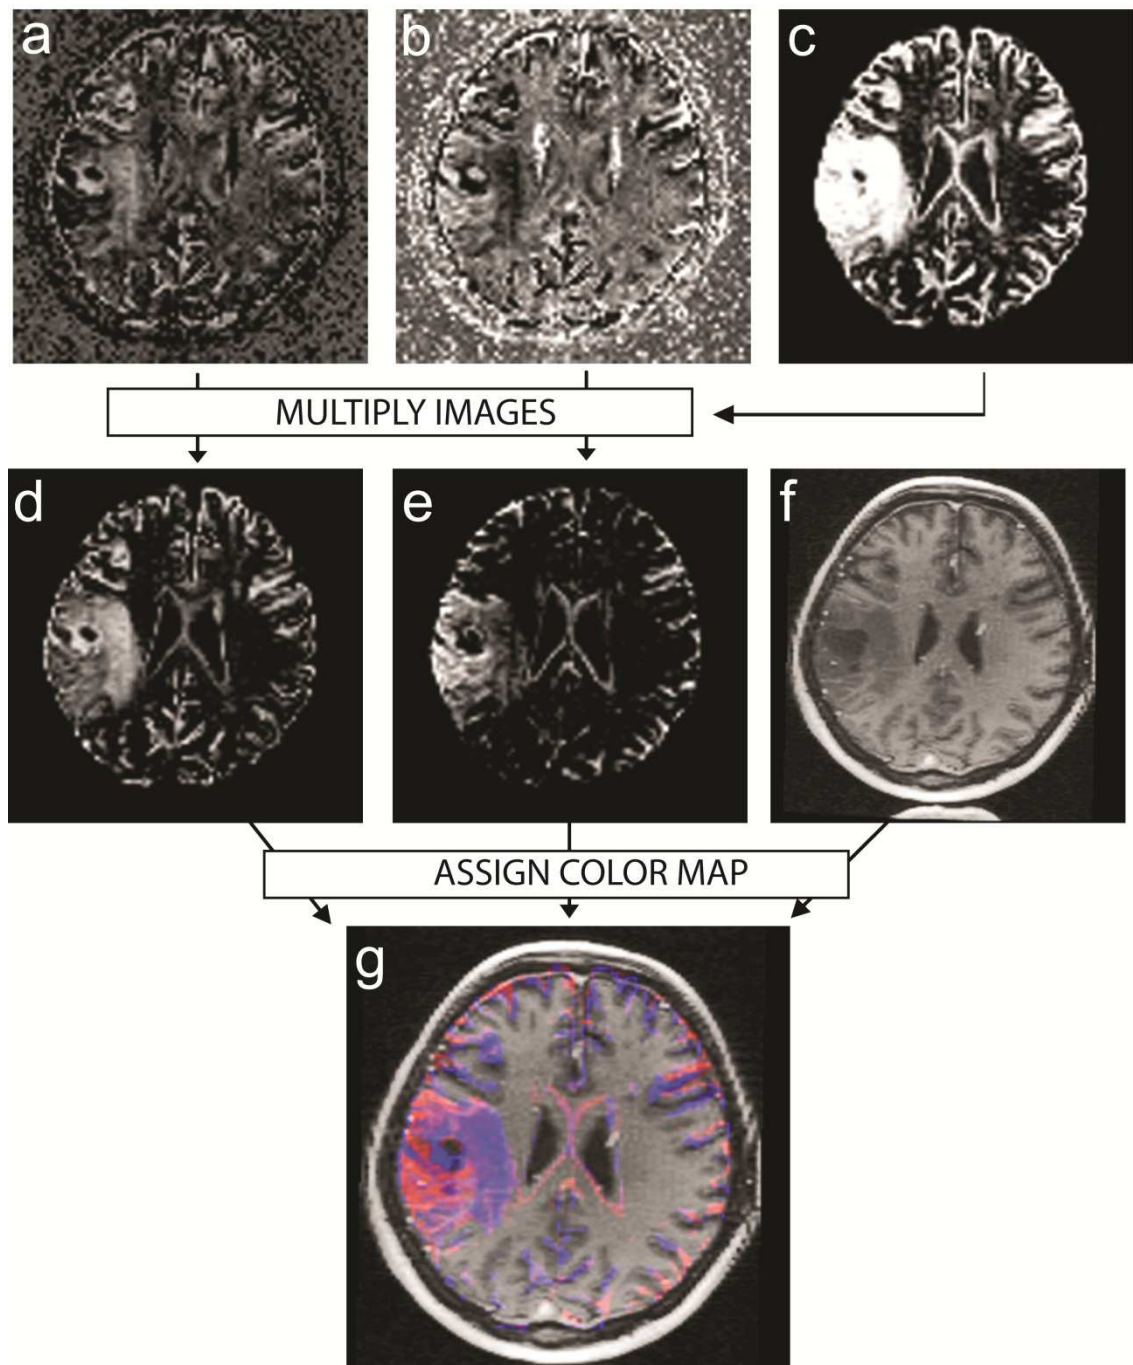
Glioma grade map generation: calculation of intermediate grayscale images and the color-coded glioma grade map (study specific aim C/2). (a) Low grade tumor probability map (LGPM), (b) High grade tumor probability map (HGPM), (c) Tumor probability map (TPM), (d,e) LGPM and HGPM weighted with the TPM, (f) T1-weighted anatomical image. (g) Glioma grade maps are generated by assigning color-code to the probability maps (d,e) and merging them with the postcontrast T1 images.
